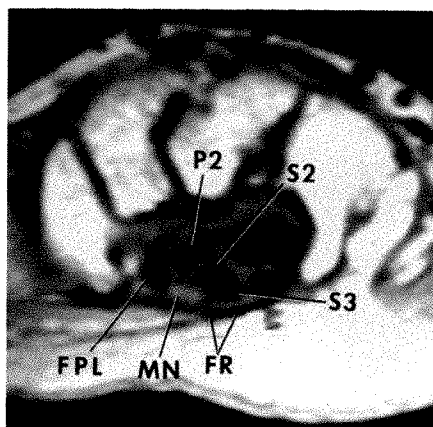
MR image (600/20) shows most common position of median nerve in a neutral wrist. It is just anterior and slightly radial to sublimis 2. (See key for abbreviations.)
